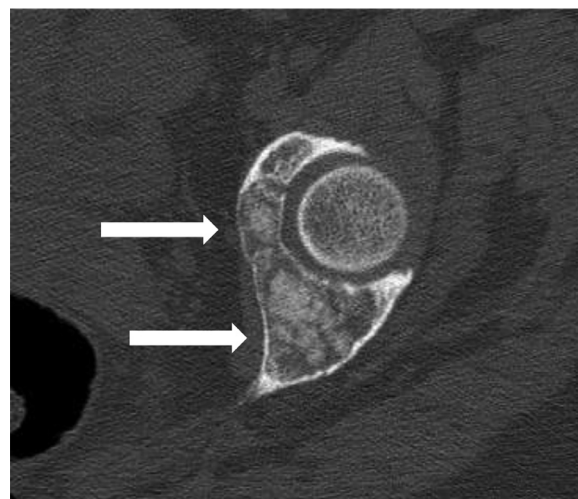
Axial noncontrast CT image of the left acetabulum in bone window soon after initial presentation demonstrating a 5.1×4.8 cm mixed lytic and sclerotic lesion (white arrows) with internal matrix calcification.
